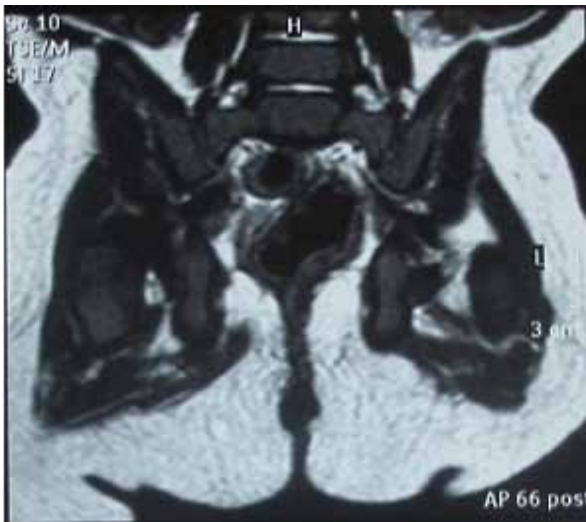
MRI coronal section with centrally positioned rectum
